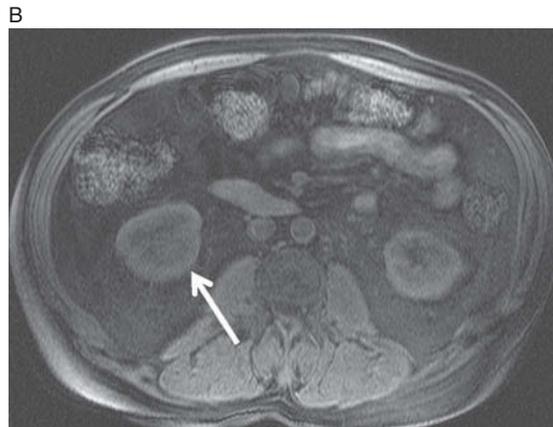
Metastatic disease to the kidney (arrow). Axial T2-weighted image shows a T2-dark mass in the right kidney (A, arrow) which is mildly enhancing and somewhat infiltrative on axial T1-weighted, fat-saturated pre- and post-contrast images (B, C). In retrospect, this would be an unusual appearance for an RCC but the key to this diagnosis is to know that the patient has a lung primary. This was the only site of extrathoracic disease and was therefore proven by biopsy.
